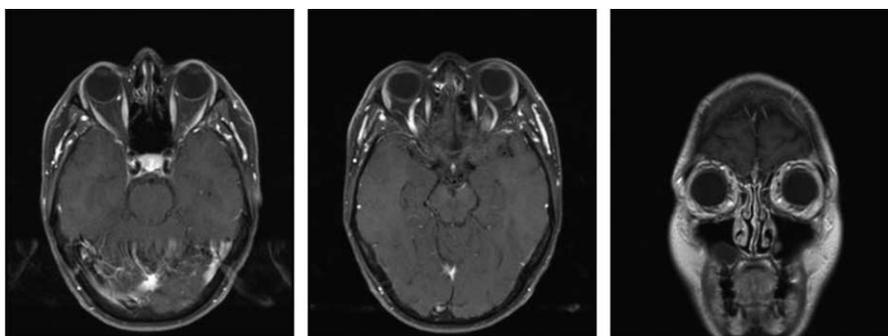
Magnetic resonance imaging (MRI) of the brain shows no evidence of uveal lesions.
